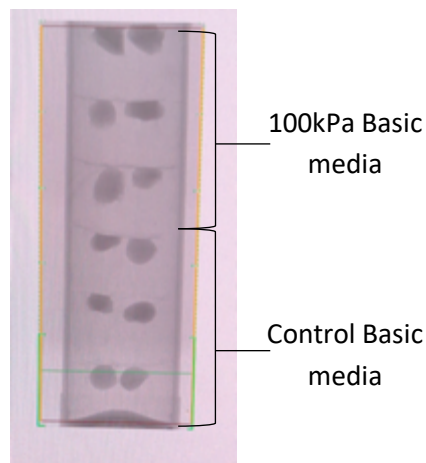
Example arrangement of samples in imaging tube for μ CT.
